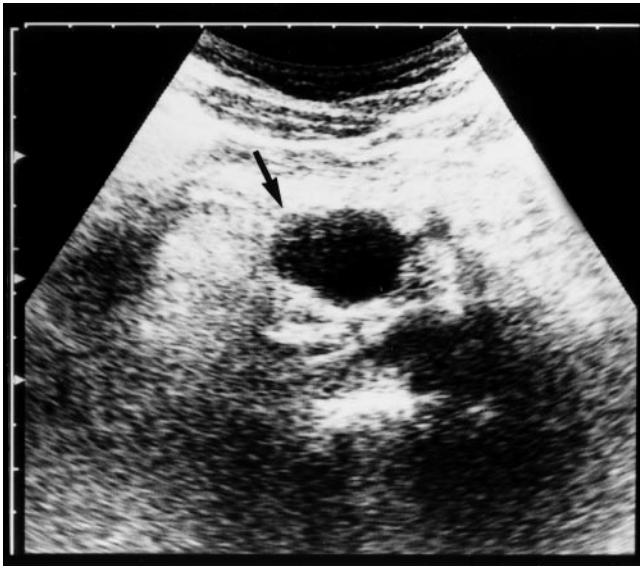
Epigastric transverse ultrasound scan shows a clearly bordered sonolucent mass in the uncus of the pancreas (arrow)
